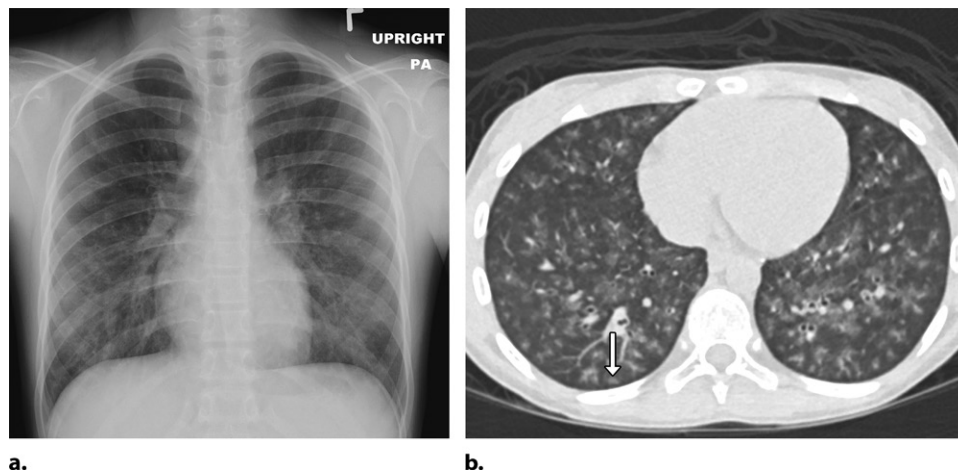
Mycoplasma pneumoniae in a 12-year-old girl. (a) Posteroanterior (PA) chest radiograph shows bronchial wall thickening and mid and lower lung zone predominant heterogeneous opacities involving both lungs symmetrically. There is relative sparing of the lung apices. (b) Axial chest CT image (lung window) obtained at the level of the ventricles shows diffuse bilateral centrilobular nodules (arrow), peribronchovascular ground-glass opacities, and bronchial wall thickening, findings commonly seen in mycoplasma pneumoniae. (Reprinted, with permission, from reference 100.)
